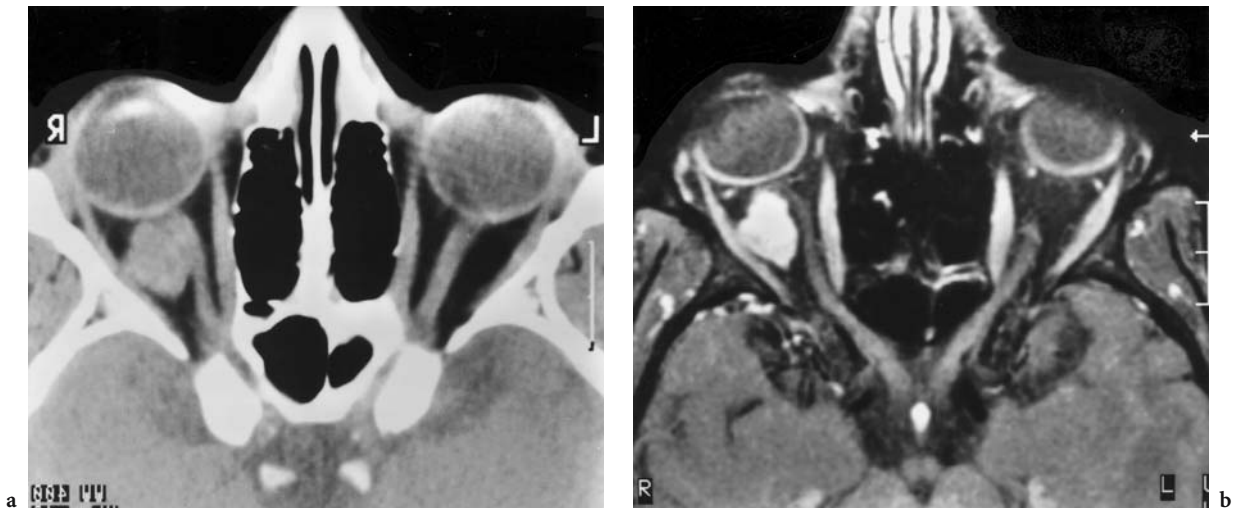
A 14-year-old boy with visual deficit and papilledema of the right eye. Diagnosis: cavernous hemangioma. CT: a Axial, native view with a sharply delineated intraconal lesion, lateral of the medially displaced optic nerve. MRI: b Corresponding T1-weighted, contrast-enhanced (FS) image with superior tumor differentiation lateral of the dislocated optic nerve. (With permission of MÜLLER-FORELL and LIEB 1995b)
